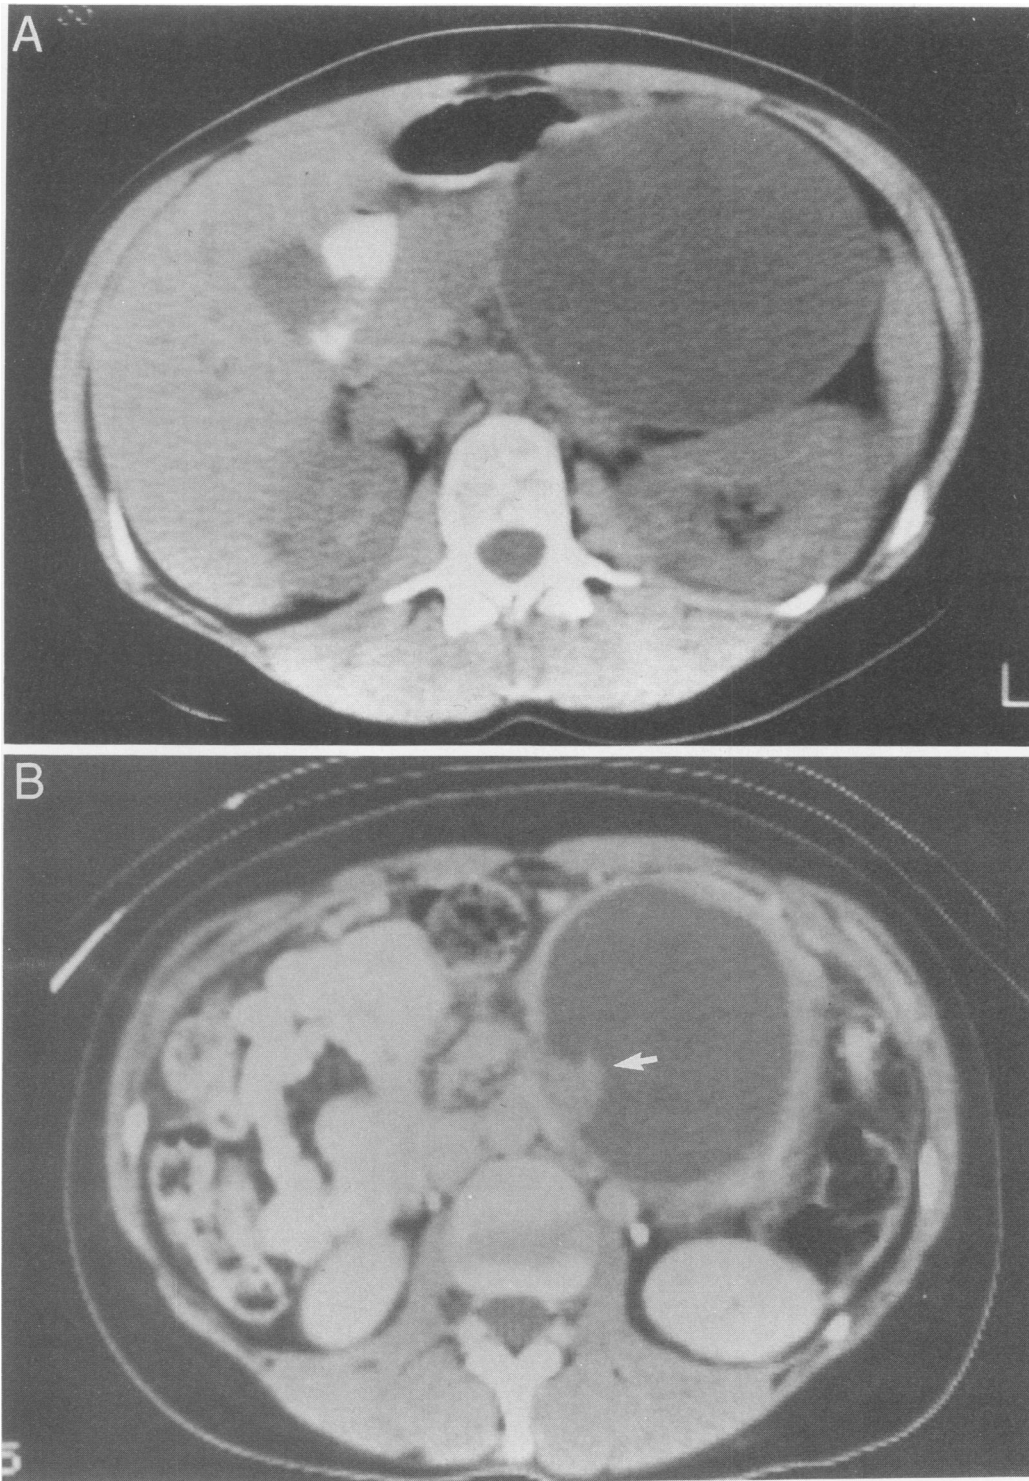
Computed tomographic scans of two mucinous cystadenocarcinomas. Solid excrescences were present within the cyst cavities of both but were visible on scan in only one (arrow).
